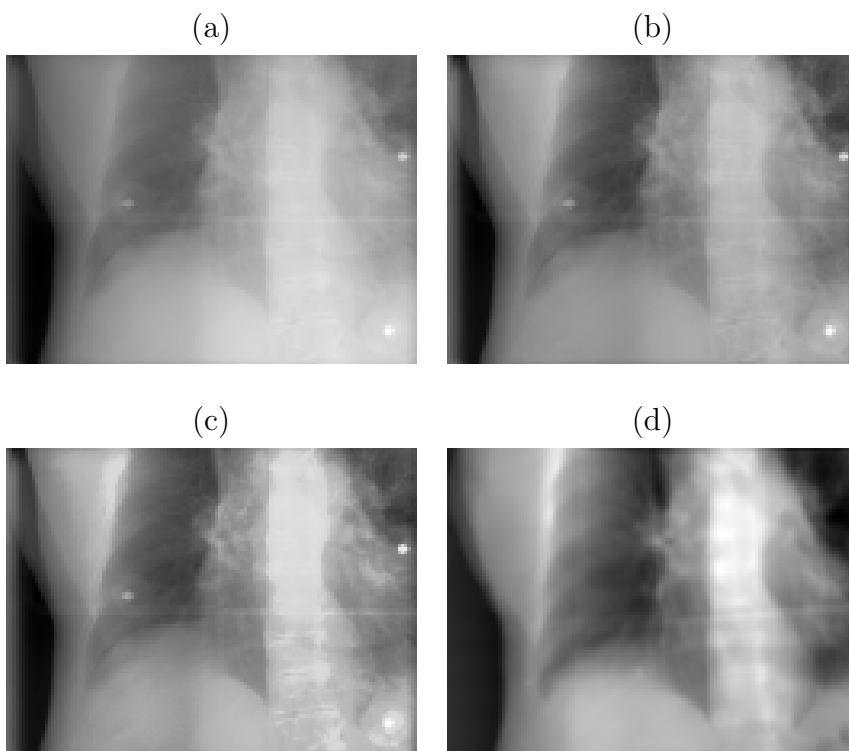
(a) A raw Cone-Beam CT (CBCT) projection (target projection), (b) a local Gaussian normalized CBCT projection (normalized target projection), (c) histogram matched CBCT projection (normalized and histogram matched target projection) and (d) a local Gaussian normalized DRR of a Fréchet mean CT (learning projection) from a lung dataset. As shown in the images, after normalization and histogram matching, the intensity contrast in the target projection becomes closer to that in the learning projection.
